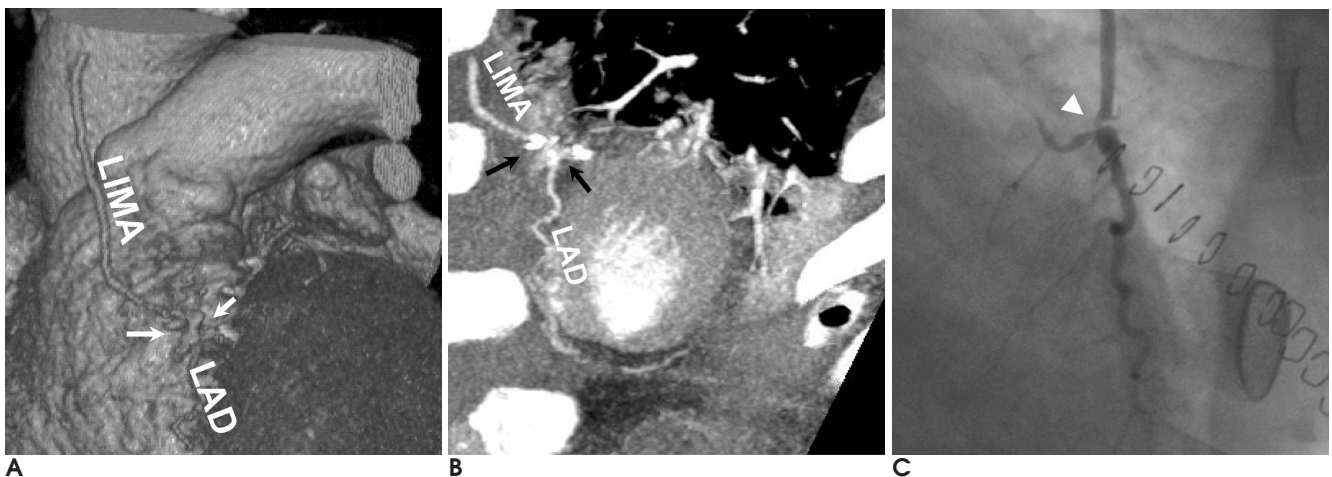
An example of false negative diagnosis. A 67-year-old male patient received CABG surgery, 10 days before coronary CTA and CAG. The heart rate was 71 bpm. Graft vessels are interpreted as patent even though the anastomosis site between LIMA and LAD (arrows) is not clearly visualized due to adjacent surgical clips and beam hardening artifacts on both VRT (A) and selected MIP (B) images. However, on CAG (C), there is significant stenosis in anastomosis site (arrowhead).
